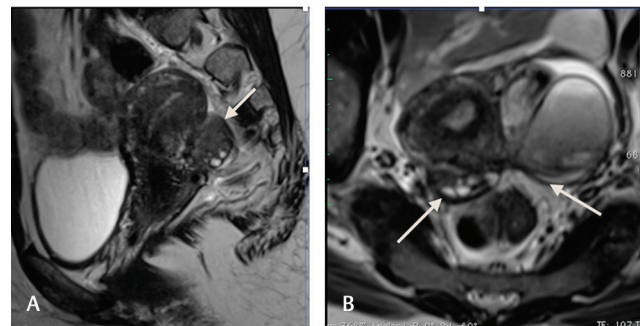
(A, B) T2W sag (A) and axial (B) images showing adherent ovary to the posterior surface of the uterus (arrow in A) and both ovaries puckered posteriorly and to the midline (arrows in B)—kissing ovaries sign. T2W, T2-weighted.
